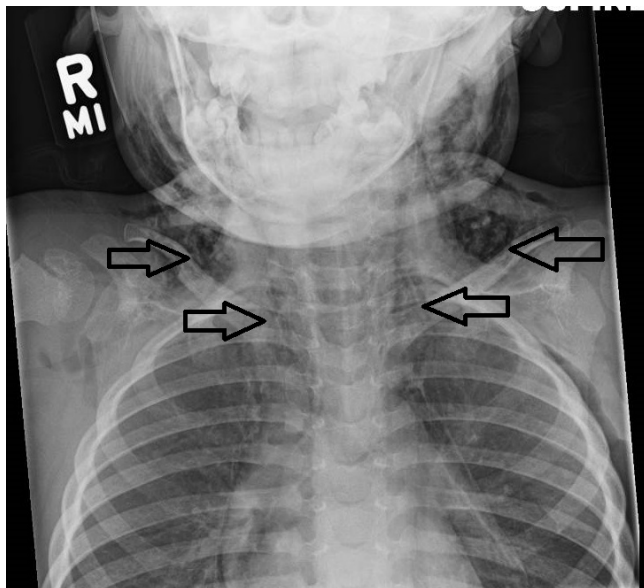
Chest radiograph showing evidence of pneumomediastinum. Note the *arrows* showing the presence of air within the mediastinum, which is a concern for an injury to the trachea or esophagus.
